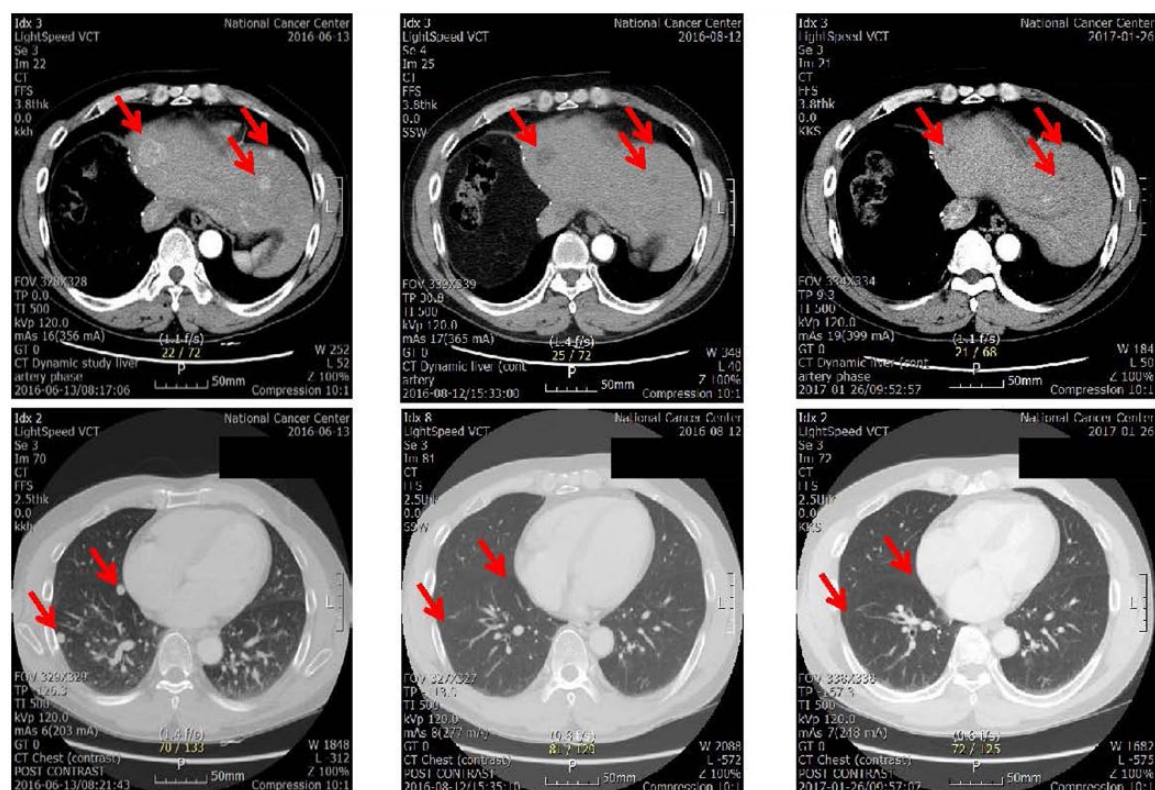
A case of immune checkpoint inhibitor treatment. A 58-year-old male patient had right lobectomy for a 17 cm-sized hepatocellular carcinoma and multiple recurrence in remained liver and metastasis in the lung developed after 4 months. He enrolled in a clinical trial with immune checkpoint inhibitor; 2 months later, computed tomography revealed complete remission in modified RECIST, a response that continued.
